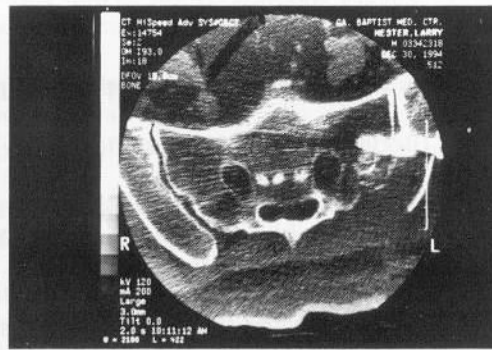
CT scan showing appropriate placement of screws across SIJ.
